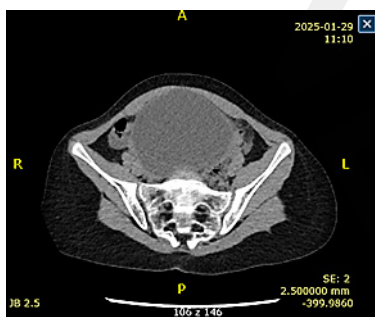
Computed tomography (Case 3)
